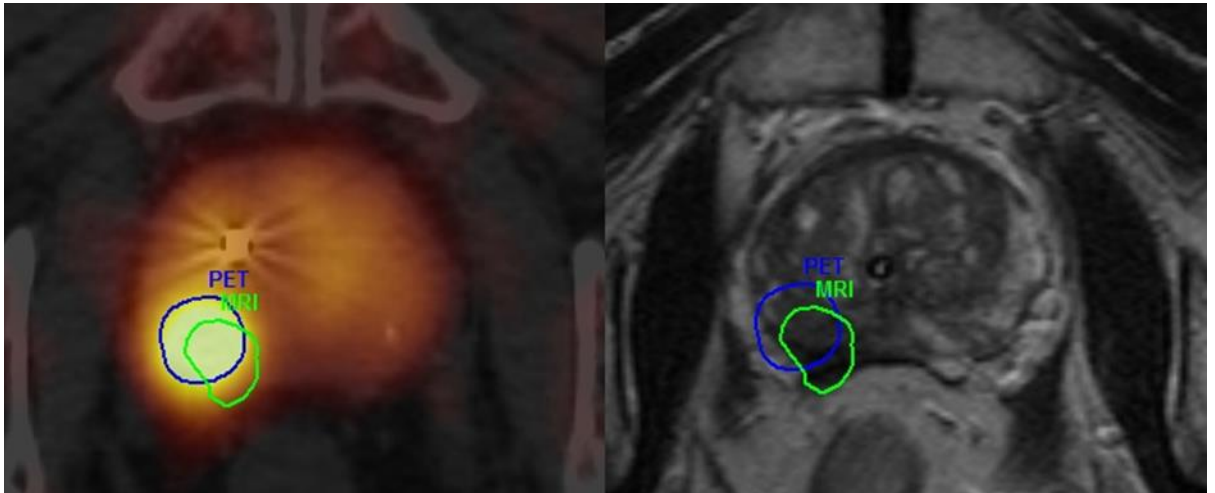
Example of a patient who had PET/CT (left) without bicalutamide. The DIL identified visually on PET overlaps the corresponding DIL identified on MRI (right).
